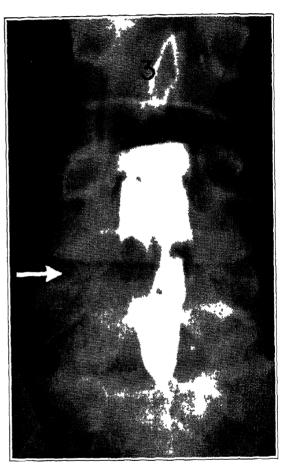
The rupture is unusually large and presents somewhat the appearance of an intradural tumor, but its extradural position can be readily established by roentgenograms in the lateral view. The patient is in the upright position, and there is complete filling above the lesion. Ruptured disk was found at operation. (Courtesy, Jour A. M. A., Oct. 16, 1937.)
